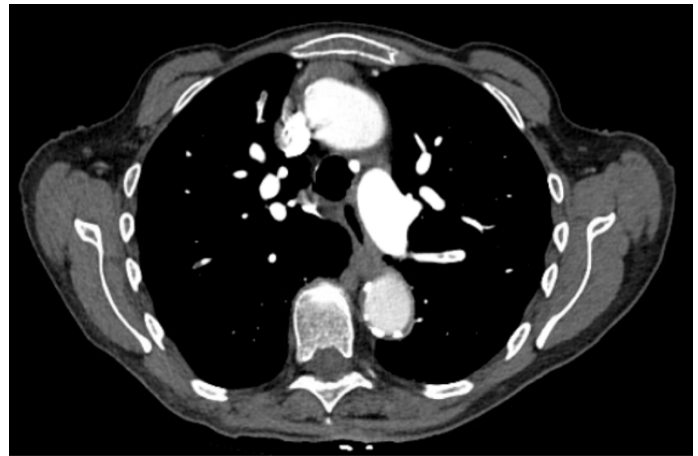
CTA Chest showing multifocal acute and new pulmonary thromboemboli with several areas of improved pulmonary thromboemboli and other old areas of thrombus. CT evidence of considerable right heart strain with RV/LV ratio calculated at 2.
